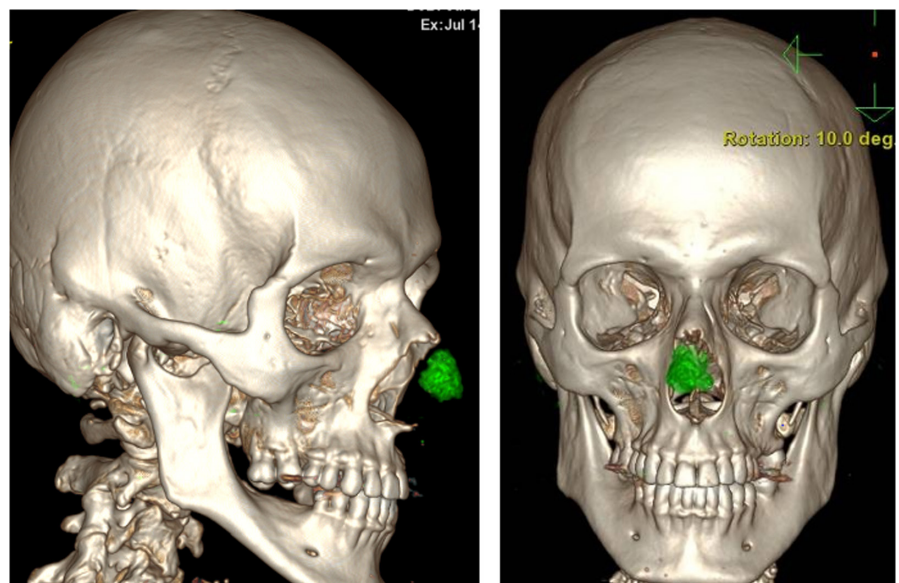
Dual-energy computed tomography for detection of monosodium urate deposits (green) in the cartilaginous septum of the nose
